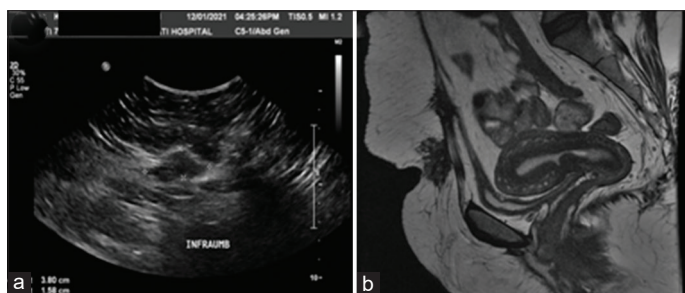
(a) Endovaginal ultrasound showing hypoechoic lesions suggestive of endometriotic scar deposits. (b) Sagittal view of MRI showing area of heterogeneously increased signal intensity (case 1)
